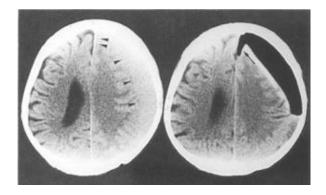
shows two CT scans side by side. The one on the left is before the surgery, and the one on the right is after. This case is an example of an interhemispheric type. In the postoperative scan, you can see that the hematoma (marked by arrowheads) involves the space between the two halves of the brain (interhemispheric space). Additionally, oxygen can be seen in the same region (indicated by the arrow), demonstrating the characteristic feature of the peaking sign.
